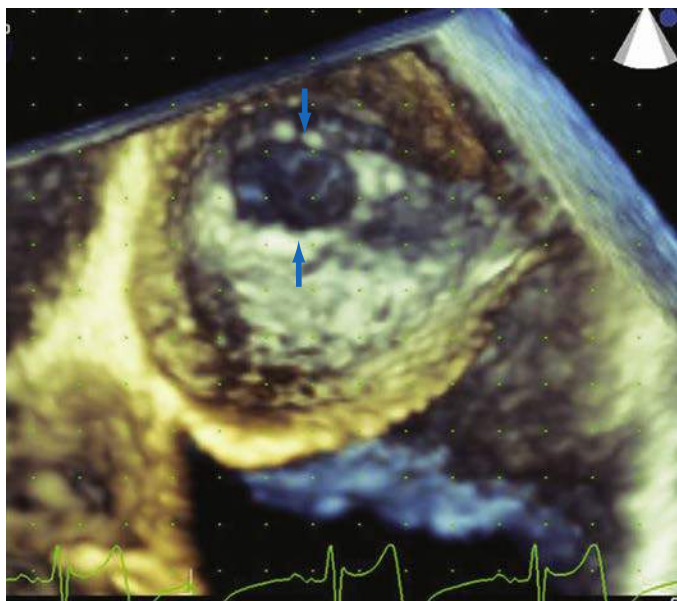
Three-dimensional transesophageal echocardiogram image from a patient with cor triatriatum demonstrating a membranous structure in the left atrium (LA) that separates the LA into two parts. The blue arrows point to the restricted defect on the membrane.
